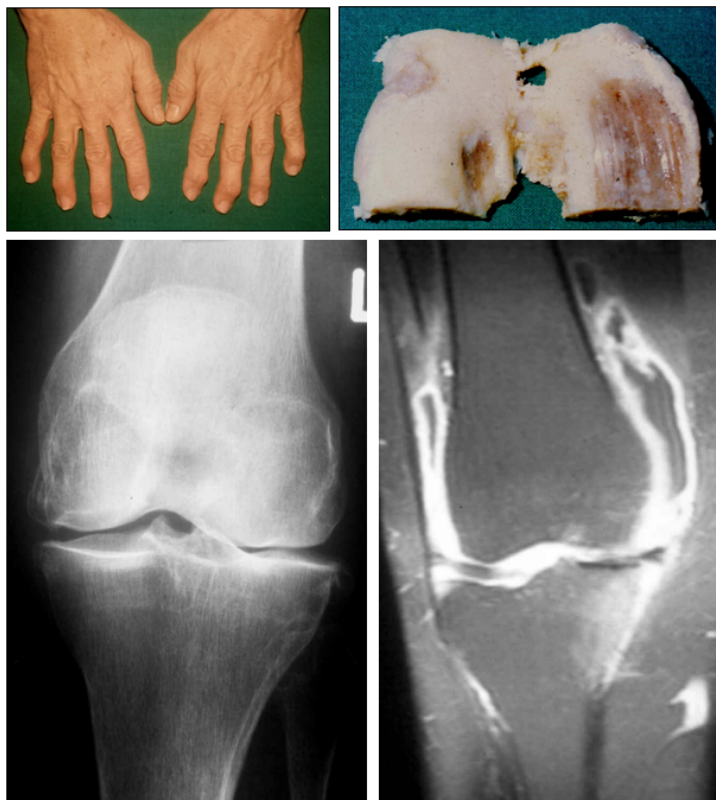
Clinical presentation of OA. Top left: Photograph of the hands of an OA patient with common features of OA: affection of the distal interphalangeal joints with the formation of hard knobs ("Heberden's nodes") and the first carpometacarpal joint (base of the thumb, "Rhizarthrosis"). Another feature of OA is the formation of knobs at the proximal interphalangeal joints (Bouchard's nodes). Top right: Surgical resectate of knee joint cartilage with severe abrasions. Bottom left: X-ray of an OA-affected knee with asymmetrical joint space narrowing. Bottom right: Magnetic resonance imaging (MRI) of an OA-affected knee. High intensity (light color) indicates inflammation of the synovium as well as the bone lining.
